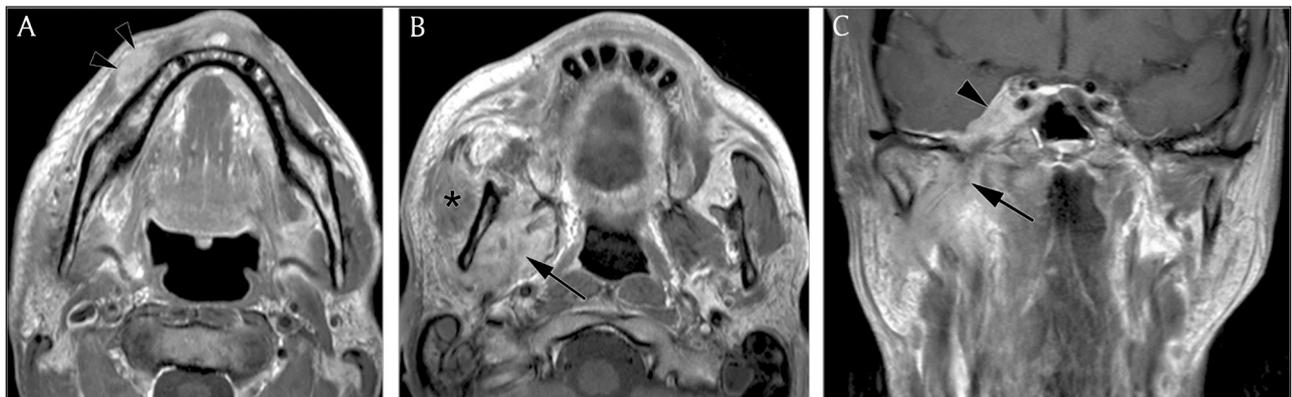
Gadolinium-enhanced T1-weighted spin echo images in a patient with a lower lip squamous cell carcinoma. The mass is centred on the mental foramen in the axial plane (A, arrowheads) and grows along the inferior alveolar nerve, a major branch of the mandibular nerve, reaching the other end of the mandibular canal, extending in the masticator space (B, arrow), without causing any visible mandibular bone destruction. Further extension is seen in the coronal plane along the mandibular nerve (C, arrow) through foramen ovale into the cavernous sinus (C, arrowheads). Atrophy of the muscles of mastication is seen, for example, at the level of the masseter muscle (B, asterisk).
